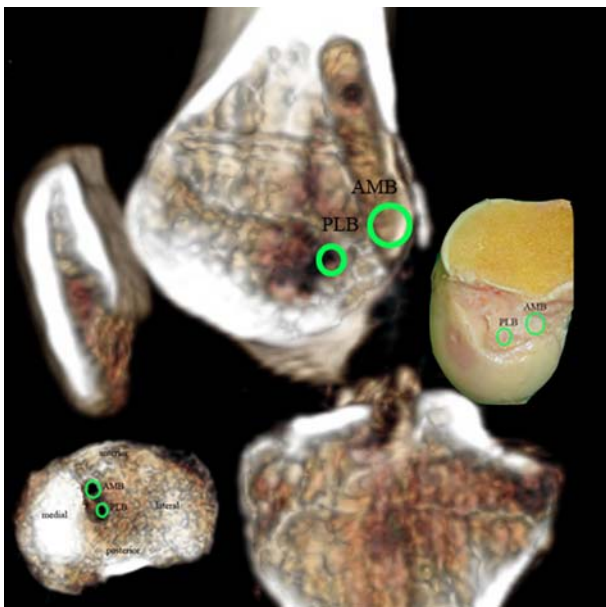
Postoperative 3-dimensional computed tomograms show the tunnels that are formed at the expected positions. A picture of the lateral condyle and tibia plateau taken with a precise medial view (AMB anteromedial bundle, PLB posterolateral bundle)
